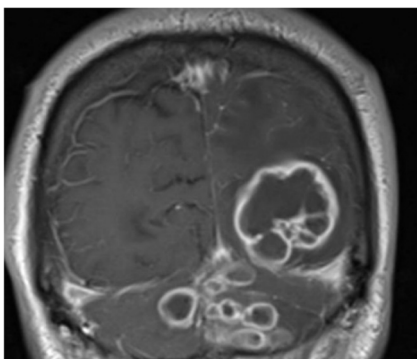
MRI Brain demonstrating numerous lesions with restricted diffusion centrally and surrounding vasogenic edema.
